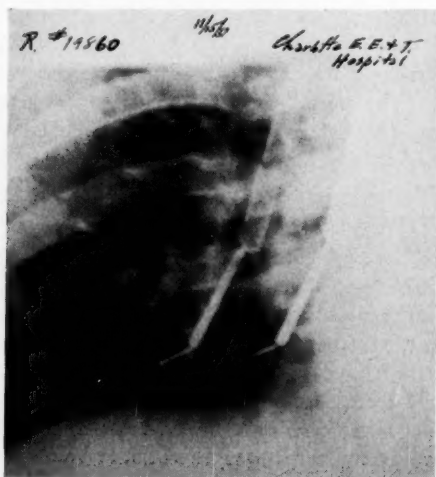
After turning the patient's head to the left (both the roentgenoscopist and bronchoscopist watching the screen), the bronchus was brought into better alignment. Magnet and attached nail were then extracted with ease.
